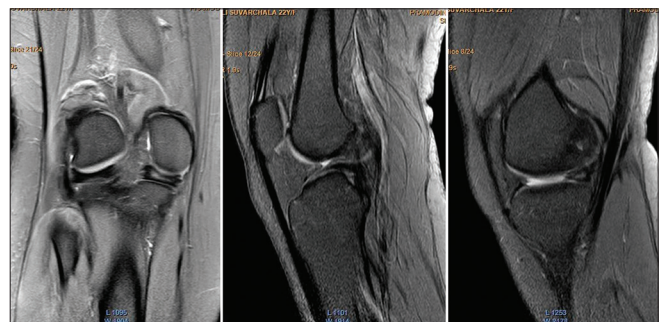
T1W MRI images showing bucket handle tear of the medial meniscus and absence of ACL. ACL: Anterior cruciate ligament, MRI: Magnetic resonance imaging, T1W: T1 weighted
